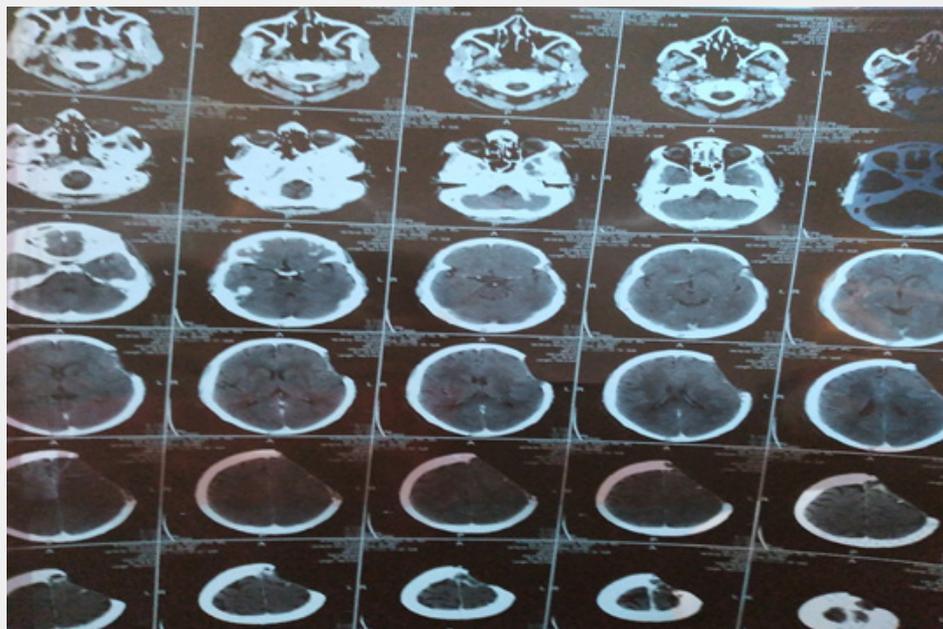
CT scan brain with contrast evident residual tumor at peripheral edge of craniotomy measure 23x20 mm on partial and 25x20 mm on left temporal.
